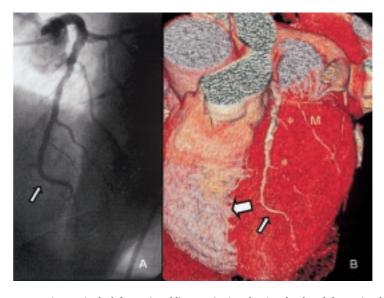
A: coronary angiogram in the left anterior oblique projection showing the short left anterior descending coronary artery (LAD) (arrow) arising from the left main branch that terminates in its middle segment. B: three-dimensional volume rendering image from the multislice computed tomography examination showing the short LAD (small arrow) and the long LAD (large arrow) that courses parallel to the short LAD in the anterior interventricular groove reaching the apex. Two diagonal branches (*) arising from the short LAD and a marginal branch (M) are also displayed in the same image.
